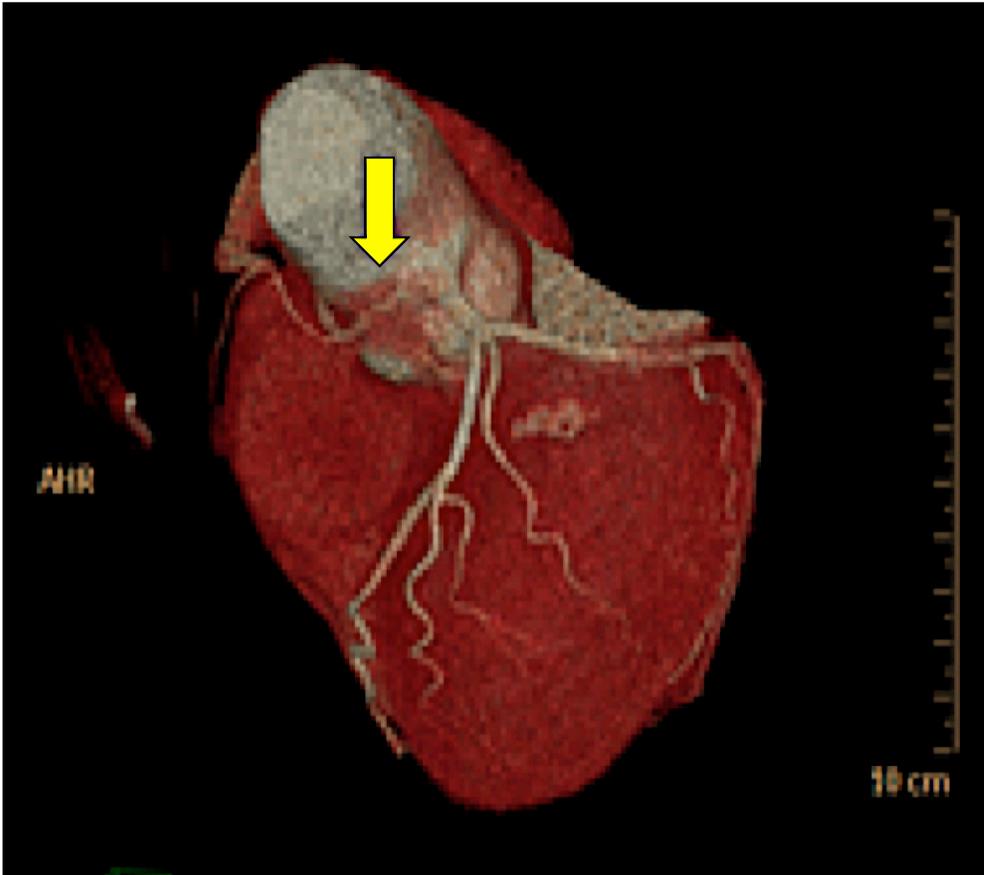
Coronary Computed Tomography Angiography 3D reformat image showing the course of THE anomalous right coronary artery RCA (arrow).
